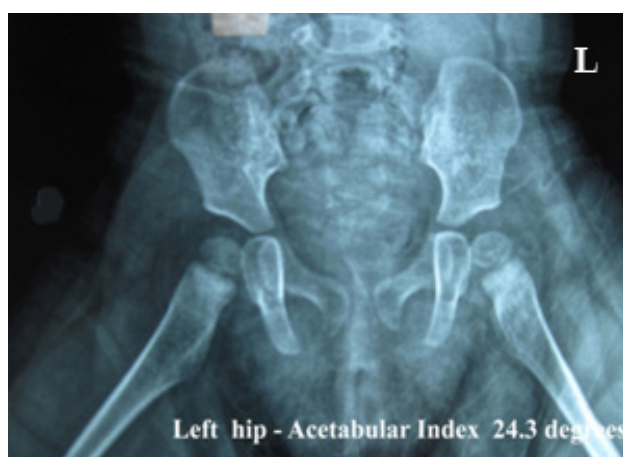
Latest Follow-Up of the roentgenography.
